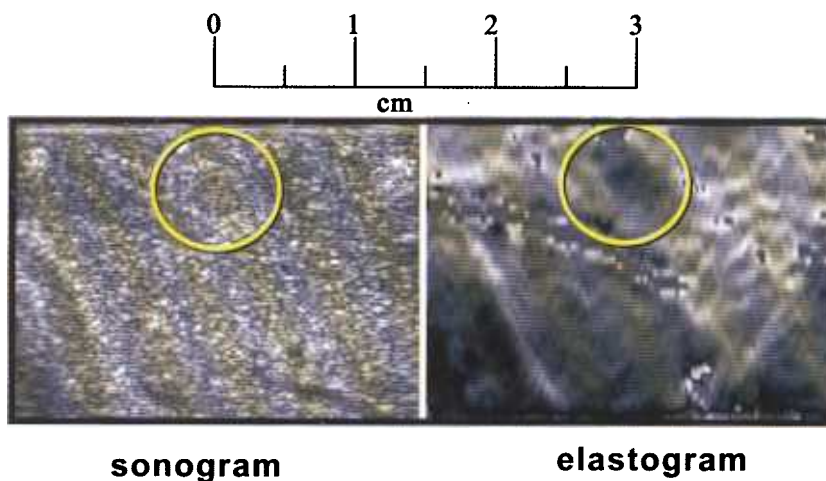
Rabbit liver in vivo, bearing a 6 mm VX2 carcinoma. Note the good contrast between the stiff carcinoma and the embedding normal liver in the elastogram, and the lack of echo contrast in the sonogram. The sonograms were taken with a Philips/ATL HDI-1000 scanner at 7.5 MHz (Merritt et al., 2002).
